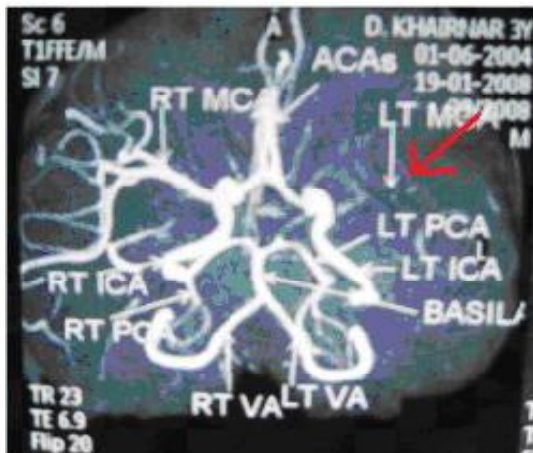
Showing MRI Angiography
